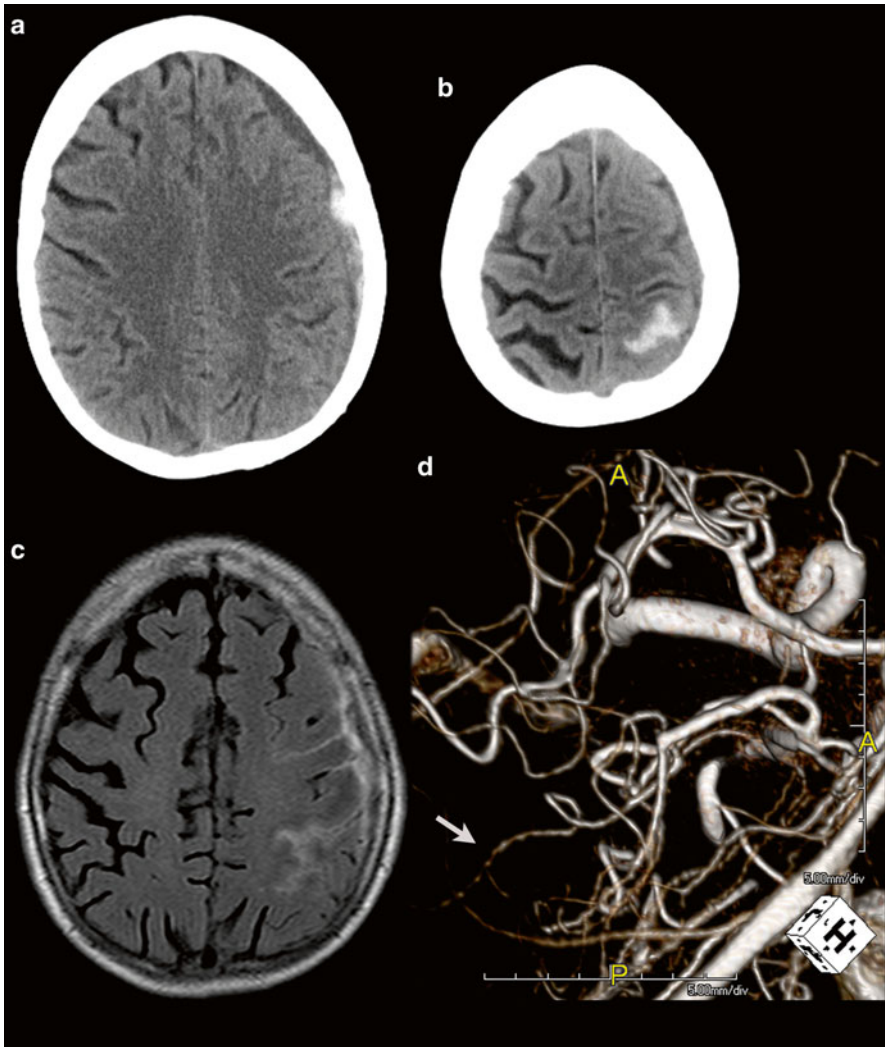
A 40 y/o female with a history of systemic lupus erythematosus (SLE) presented with headache after mild trauma. NECT shows hemorrhage in the subarachnoid and subdural space at the left side (a and b). MRI FLAIR confirms the presence of hemorrhage (c) and subsequent MRA shows vascular calibre changes (d), consistent with (SLE) vasculitis
